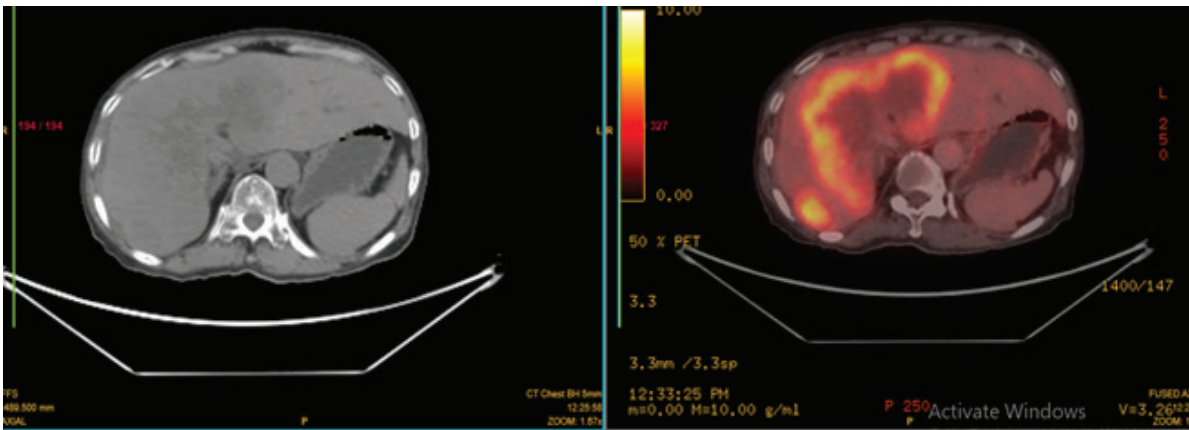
In axial scan, FDG avid large irregular heterogeneously enhancing mass with central necrosis is noted in liver, predominantly in right lobe, infiltrating porta hepatis and encasing portal vein & biliary duct, causing upstream biliary dilatation in left lobe. The mass measures about 12.6 cm (Tra) x 11.6 cm (AP) x 9.5 cm (CC) with SUVmax – 8.0. Another FDG avid heterogeneously enhancing mass is also seen in segment VII of liver (~4.8 cm x 3.4 cm x 2.4 cm).
